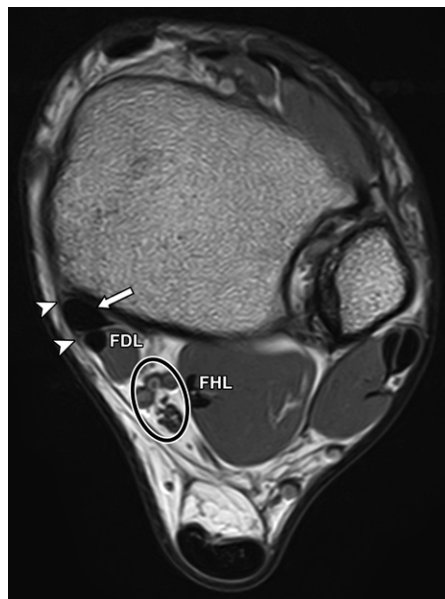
Normal PTT at the level of the medial malleolus in a 42-year-old man. Axial T1-weighted MR image of the normal ankle shows the normal PTT located behind the medial malleolus (arrow), which is covered by the flexor retinaculum (arrowheads). The smaller flexor digitorum longus (FDL) and flexor hallucis longus (FHL) tendons lie posterolateral to the PTT, with the tibial neurovascular bundle (oval outline) located between them. The PTT is best evaluated in this plane, with the sagittal and coronal planes serving as useful adjuncts for abnormalities remote from the malleolus.
